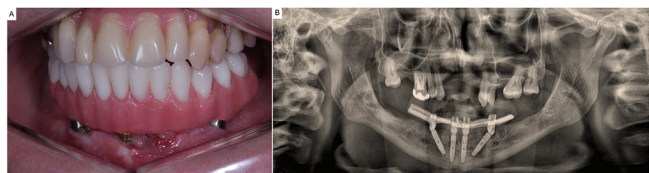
(A) Clinical image showing centralization, together with the upper removable partial prosthesis, 3 months after installation of the osseointegrated implants. (B) Panoramic X-ray image showing follow-up after 3 months. The implants are well adjusted to the lower dental arch.
